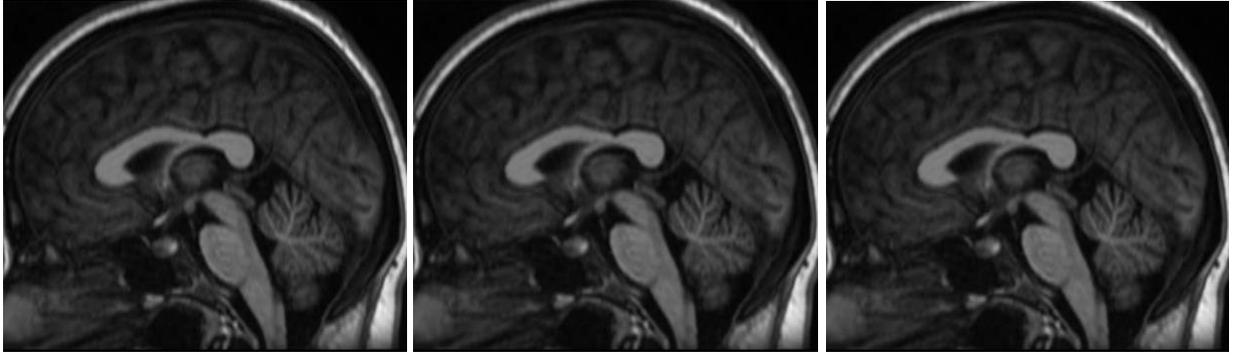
First MRI for migraine protocol in April 2024 in Germany: considered normal
